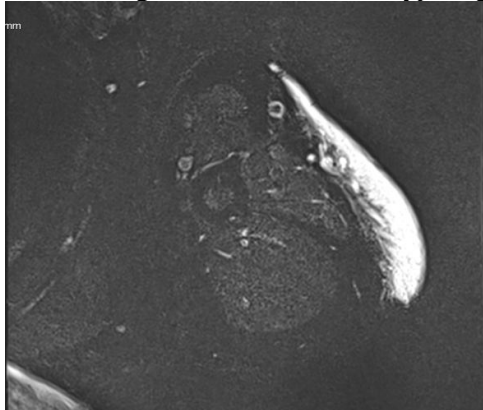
MRI of the left arm, axial section in T2-weighted FSTSE sequence: lesion process of the superior-external aspect of the arm with regular T2 hypersignal contours.
